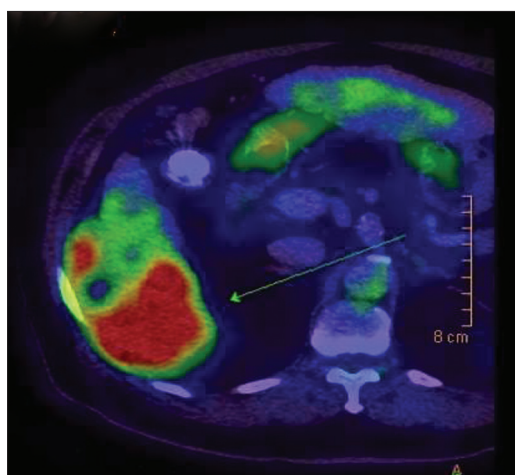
Positron emission tomography/computed tomography showing a predominantly 18F-fluorodeoxyglucose-avid liver mass suggestive of moderately to poorly differentiated hepatocellular carcinoma (SUVmax 14.2)
